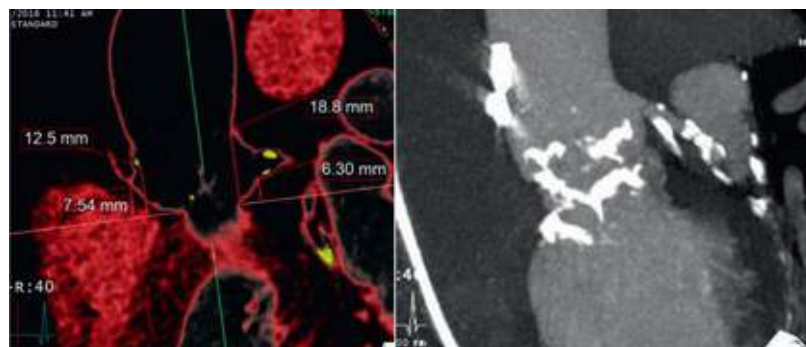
Three-dimensional CT scans. Left, Coronary height relative to the aortic annulus. Right, Calcification of the aortic root, annulus, and left ventricular outflow tract.
